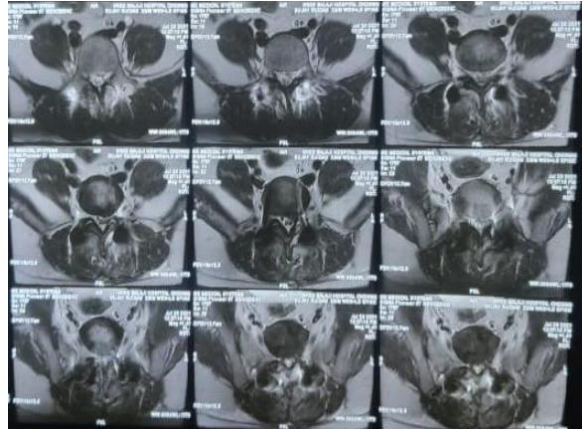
AXIAL VIEW OF MRI
